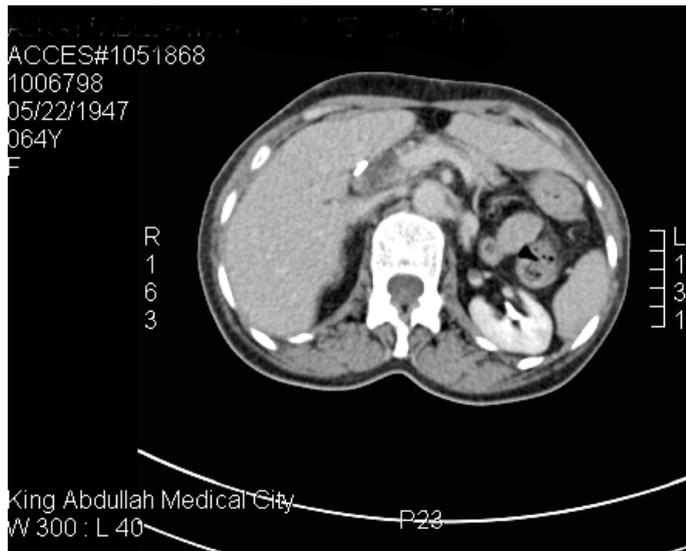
CT abdomen showing complete resolution of the previously described soft tissue mass at the surgical bed
